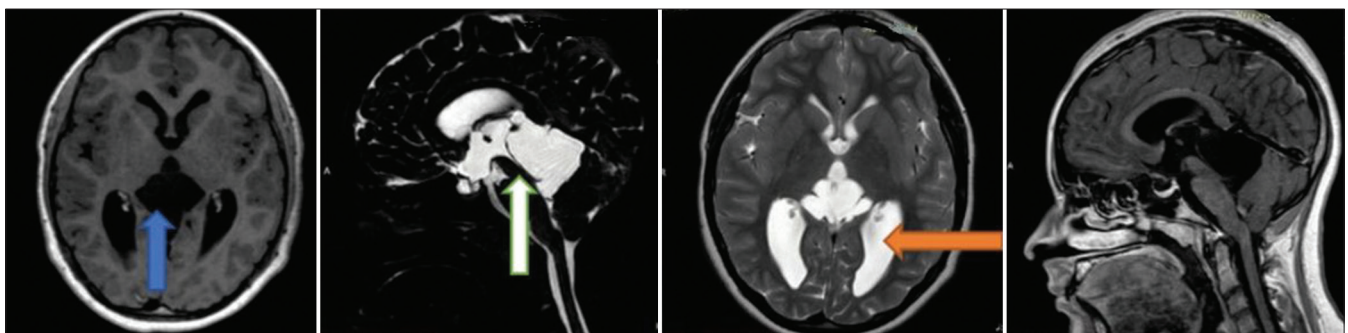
MRI of the brain on admission showing the cyst isointense to cerebrospinal fluid (blue arrow) in T1, T2, and flair, dilated ventricles (orange arrow), and compressed cerebral aqueduct (white arrow).
